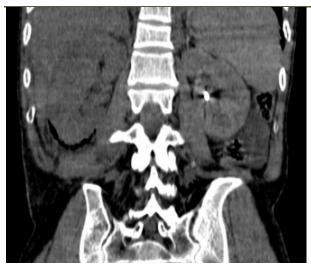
Coronal CT scan reconstruction demonstrating peri-renal gas extension beyond the Gerota fascia
